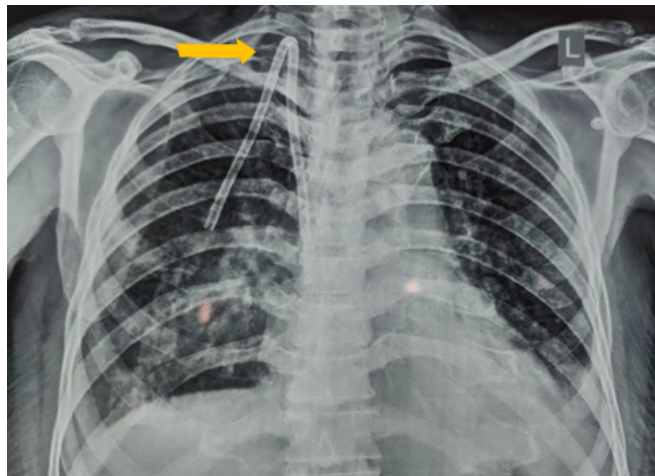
Radiographic image showing kink at IJV entry site (arrow). This kink was removed by blunt dissection of underlying soft tissues, and optimal function was restored.
